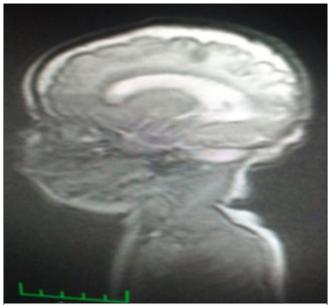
Cranial MRI shows pachygyria, incomplete lissencephaly and cerebellar hypoplasia
